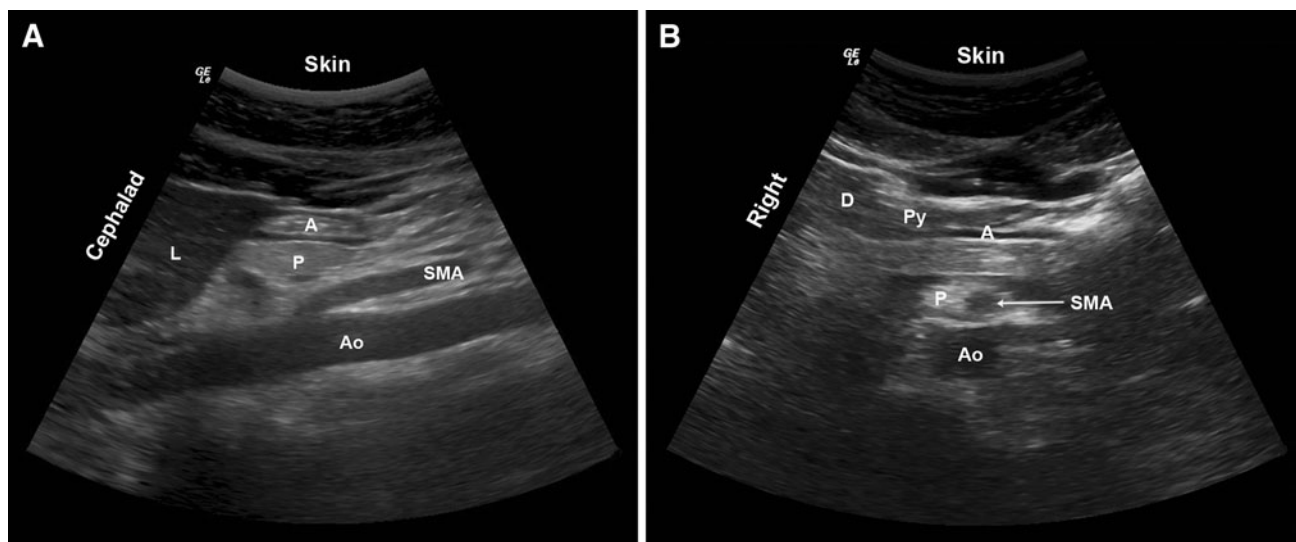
A Sagittal sonogram of the empty antrum with a flat appearance. A = antrum; L = liver; P = pancreas; SMA = superior mesenteric artery; Ao = aorta. B Axial sonogram of the empty
